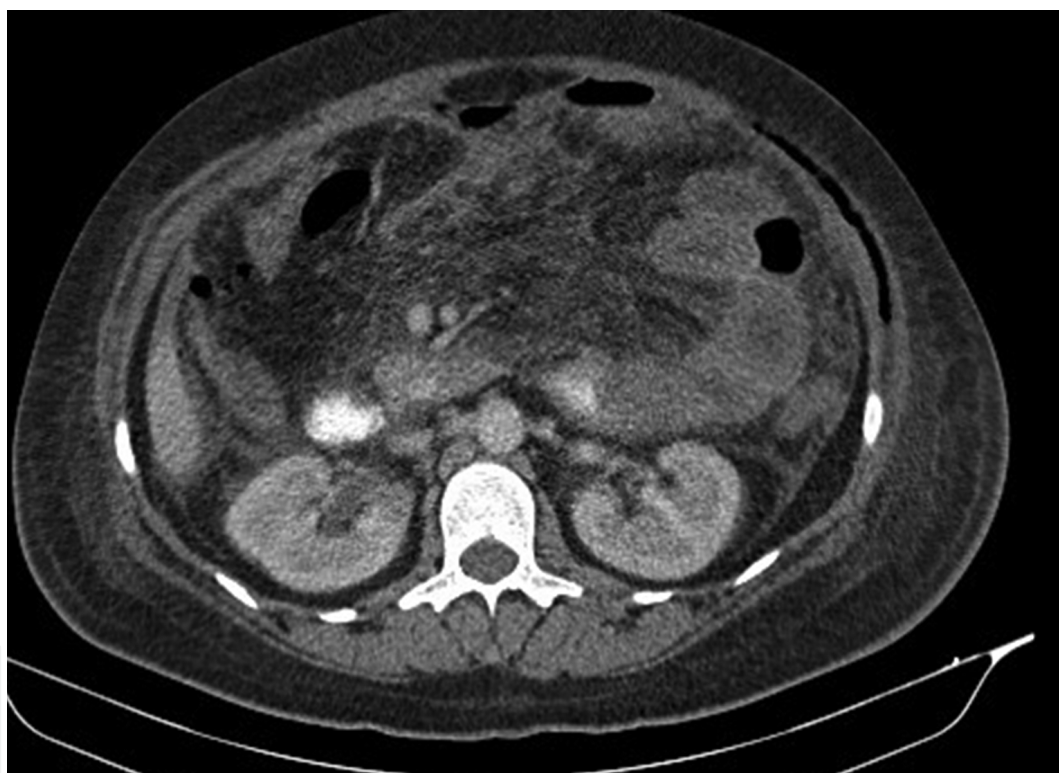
Abdominal CT showing sigmoid diverticular disease and indirect signs of perforation (mesenteric contamination and heterogeneity).
